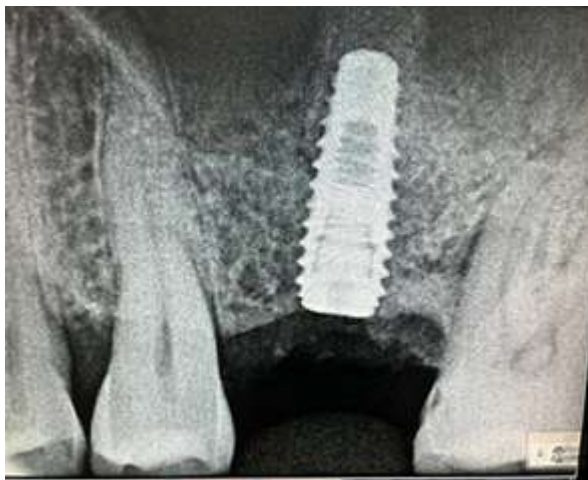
Radiograph at 6th month
